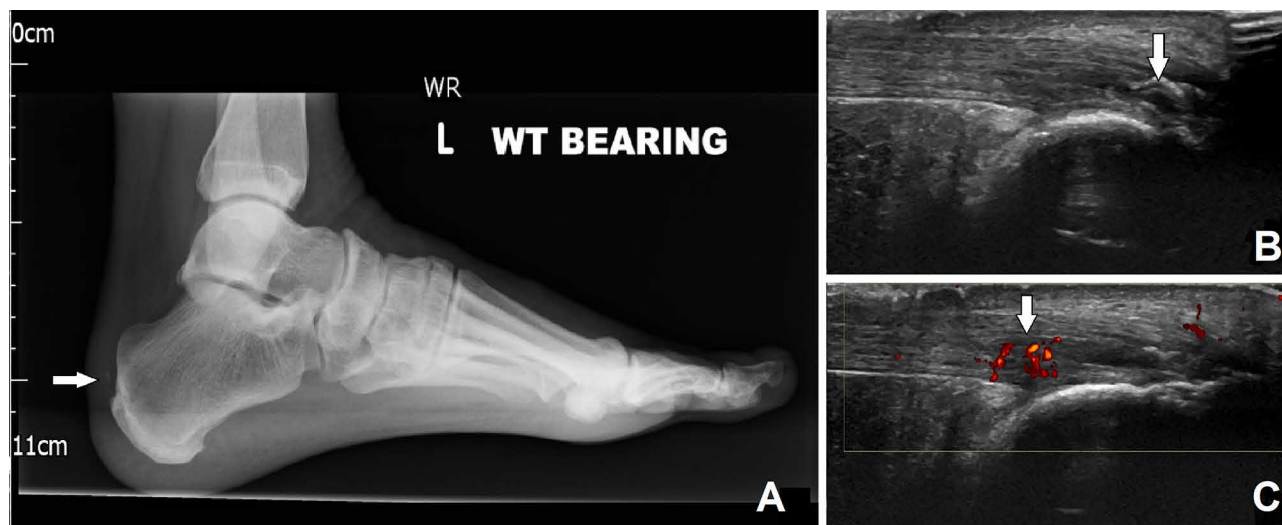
Imaging assessment. (A) Calcification (arrow) at the insertion of the tendon can be seen at plain radiography. (B) Evaluation of the lesion (arrow) through two-dimension ultrasound evaluation. (C) Power Doppler allows detection of areas of hypervascularisation of the tendon (arrow). WT bearing, weight bearing.
